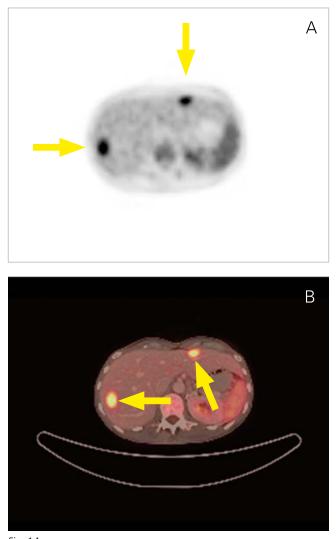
Imaging of two liver metastases with positron emission tomography (PET) (A) and combined PET/CT (B); arrows indicate the metastases
